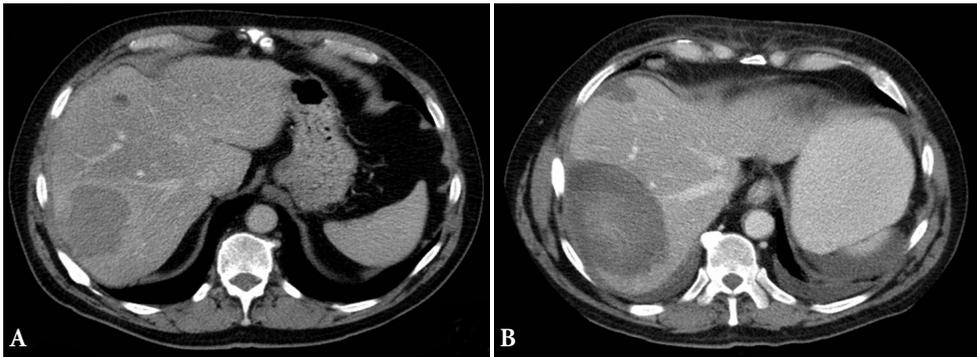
CT scan of a 63-year-old man with multiple hepatic metastases from an endocrine tumor, (A) CT scan showing a metastasis of 7.4 cm in diameter in segment VII, (B) CT scan one week after multipolar RFA showing a coagulation lesion of 12.0 cm in diameter in segment VII.
